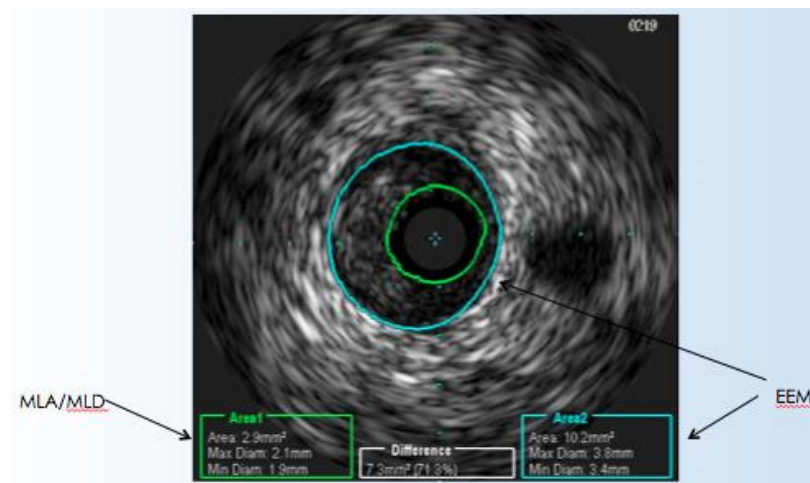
Intravascular ultrasound frame :
